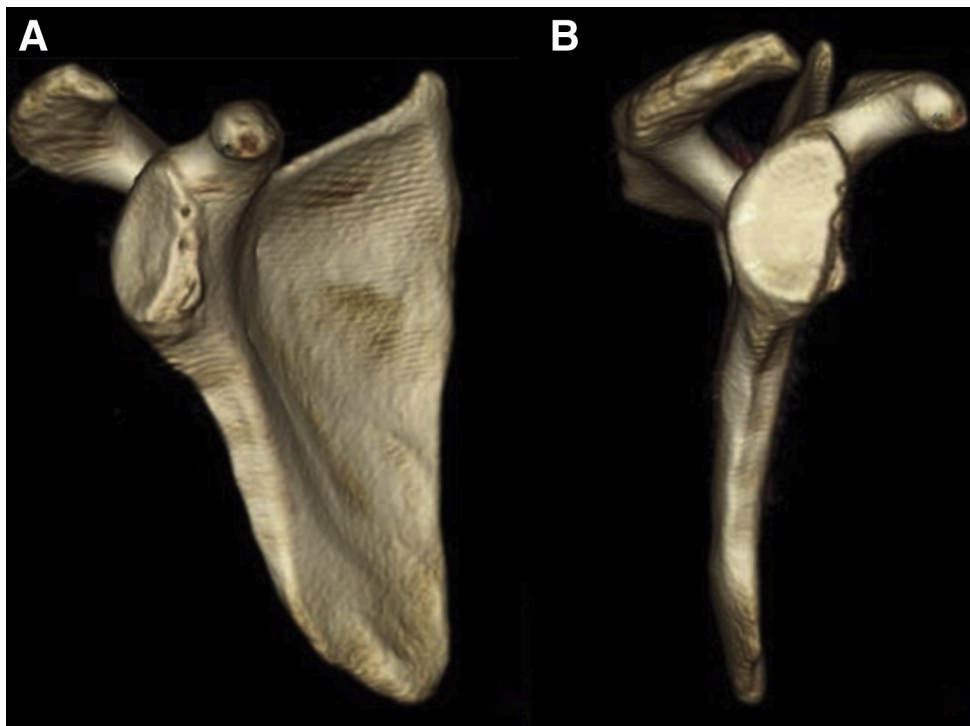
Preoperative 3-dimensional reconstructed computed tomography images of the glenoid with the humeral head digitally subtracted showing (A) an oblique view and (B) en face view of the right shoulder of a 21-year-old male patient. These images were acquired using 1.25-mm-thick slices using the BrightSpeed computed tomography scanner with the patient lying in the supine position. The significant amount of anterior glenoid bone loss should be noted.
